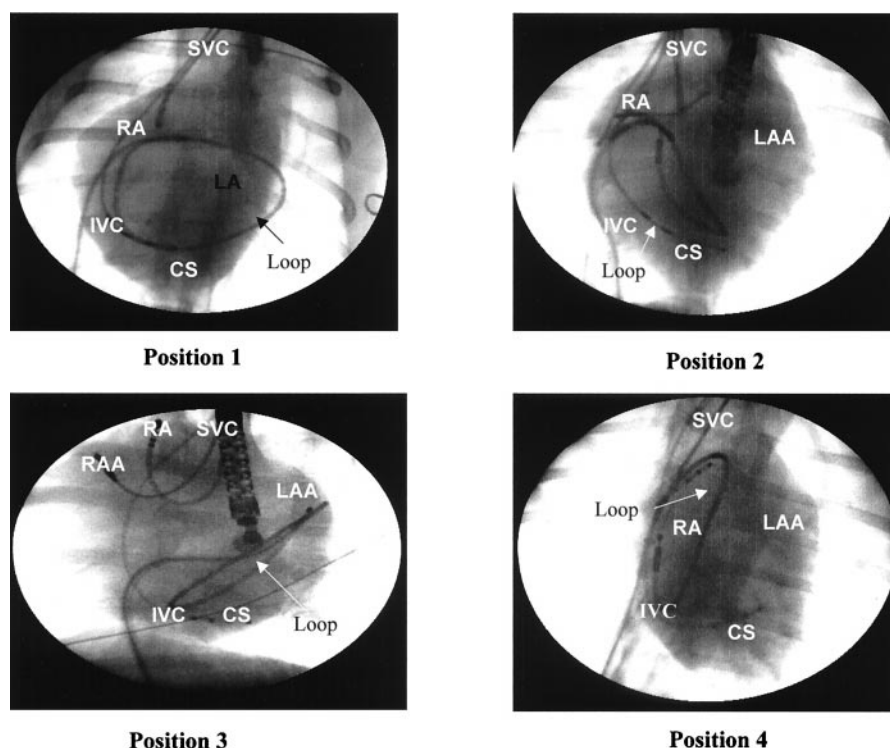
Fluoroscopic images of catheter positions for linear lesion creation. These fluoroscopic panels presented in the posteroanterior position of the C arm, showing the loop catheter deployed in the right atrium (RA) and left atrium (LA) in the positions where linear lesions were created. Standard high-RA and coronary sinus (CS) catheters and a transesophageal echocardiography probe are visible in some of the panels. (Position 1) Lesion encircling the pulmonary veins (PVs). The posterior portion of the circle is close to the mitral valve (MV) ring, as shown by the proximity of the loop to the CS catheter. The anterior segment is located under the left and right superior PVs. (Position 2) Left atrial circular lesion extending from the medial portion of the MV ring to the lateral wall of the LA. (Position 3) Left atrial circular lesion connecting the lateral portion of the MV ring and the superior portion of the atrial septum. (Position 4) Right atrial circular lesion from the inferior vena cava (IVC) across the isthmus, to the anterior septal region of the tricuspid valve ring, to the RA appendage (RAA), to the superior vena cava (SVC) and back to the IVC. LAA = LA appendage.
